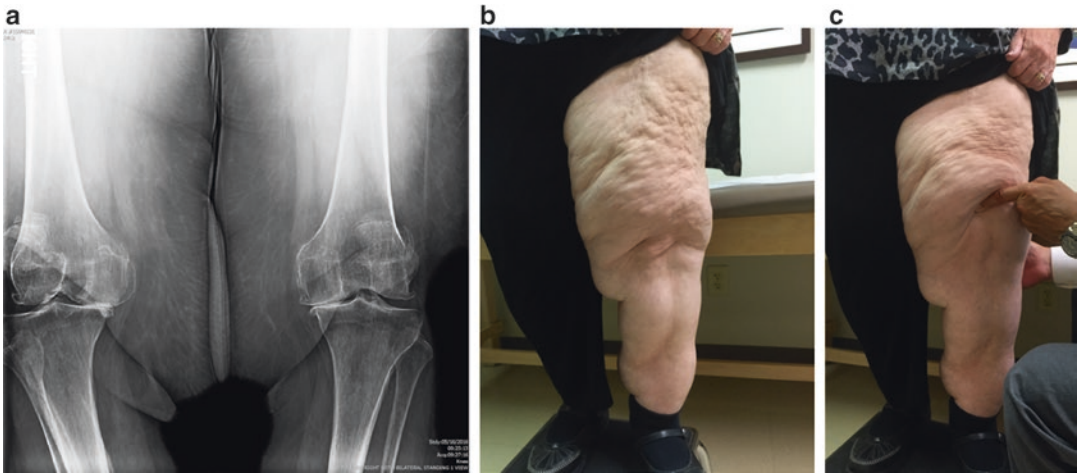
(a) Standing anterior-posterior radiograph of an obese patient with a pendulous fatty panniculus following massive weight loss. (b and c) Photographs demonstrating redundant skin overhanging the patella
